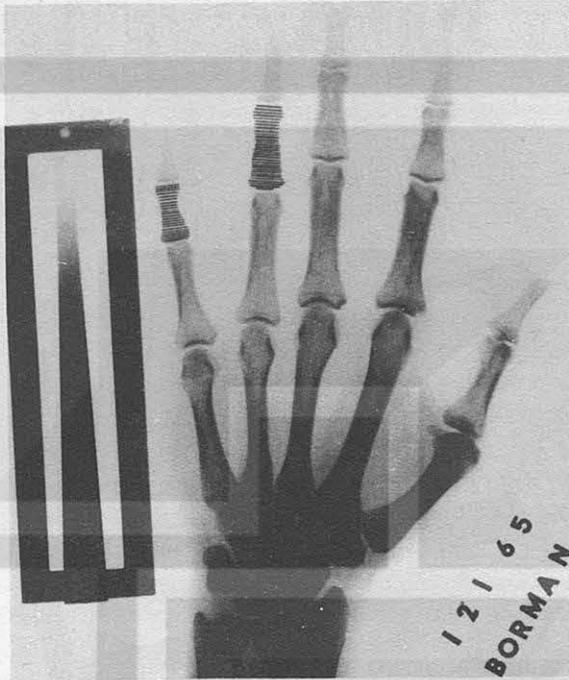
Positive print of hand radiograph in posterior-anterior projection, showing position of parallel traces on phalanges 5-2 and 4-2. The scans slightly overlap each other and cover the entire bone in each case.
